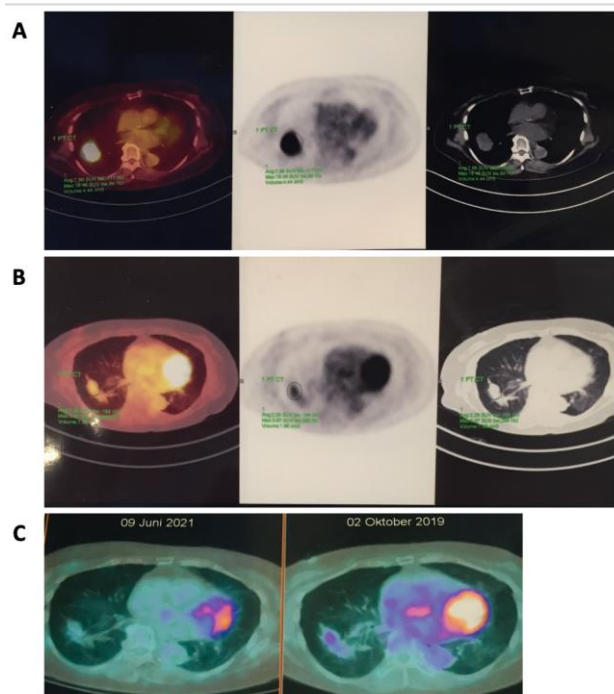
A) ¹⁸F-FDG-PET-CT scan in 2018 showed pulmonary mass with enhanced uptake; B) PET-CT scan taken 1 year later show stable disease; and C) PET-CT scan after 3-years therapy showed decreased mass with fibrotic loci and no metabolic activity.
